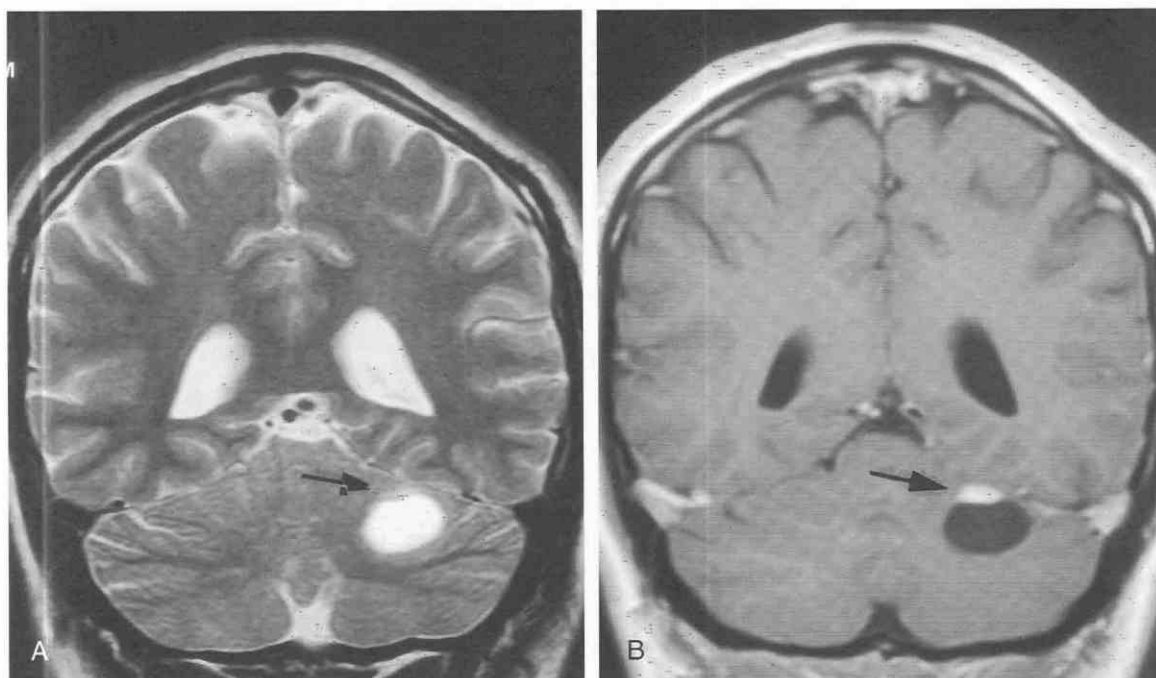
Hemangioblastoma of the cerebellum. *A*, A coronal T2-weighted MR image demonstrates a sharply margined ovoid hyperintense mass in the superior aspect of the left cerebellar hemisphere. On the superior margin of this cystic mass, a flat nodule that is isointense to adjacent gray matter is identified (*arrow*). *B*, Following intravenous administration of gadolinium, a coronal T1-weighted image demonstrates intense homogeneous contrast enhancement of the mural nodule (*arrow*), which is located on the superior surface of the cerebellum. The adjacent cyst is hypointense, and its margins do not demonstrate contrast enhancement.
